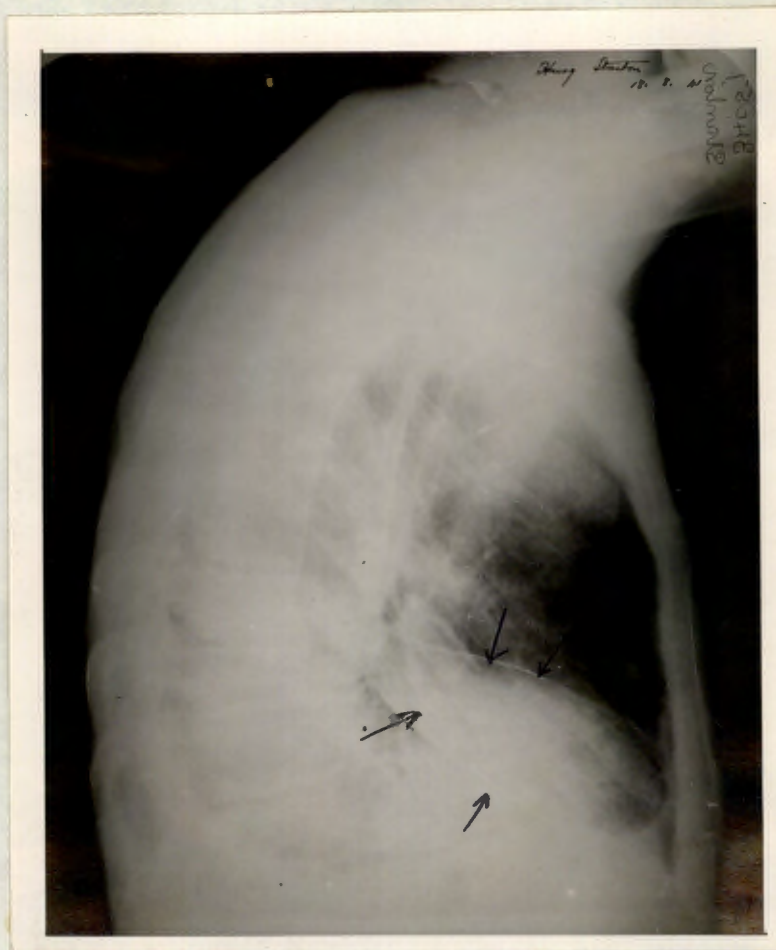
Lateral radiograph of a right lung. In addition to consolidation of the middle lobe, the depressed fissure shows the presence of an element of collapse as well. There is also a little fluid at the base.
